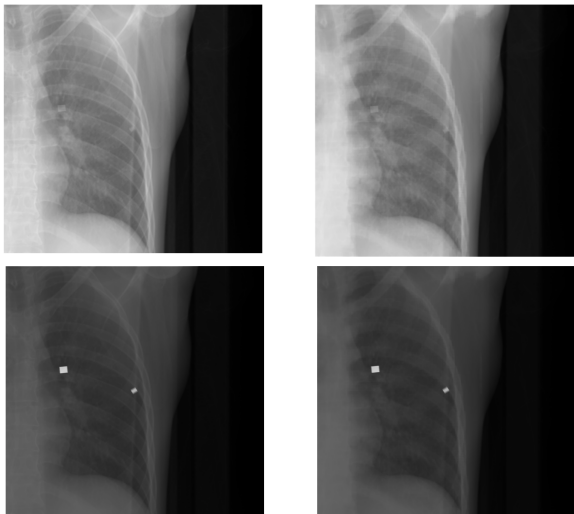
Example of nodule segmentation to be inserted in CT volume prior to imaging in silico. Each nodule was randomly rotated, scaled, and inserted randomly within the organ of interest.
